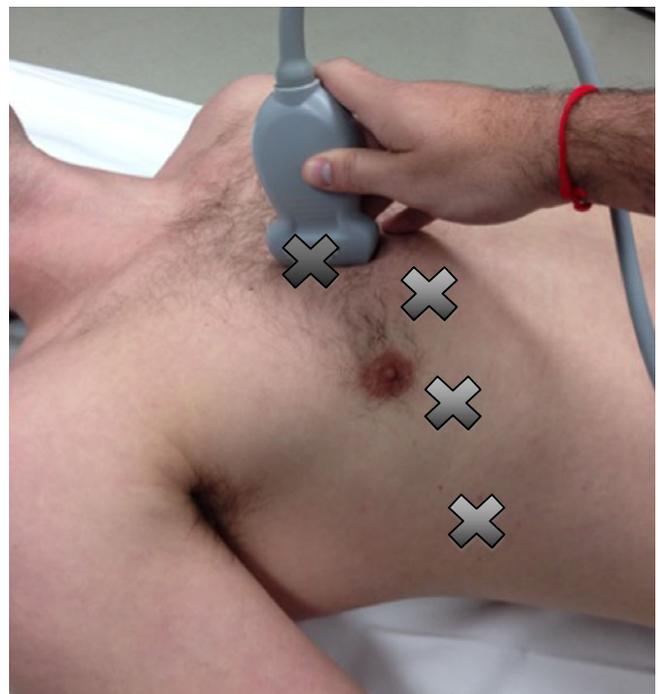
Ultrasound probe placement. The single-view protocol is marked by the probe at the first X. The following X's mark the additional views for the four-view protocol.
